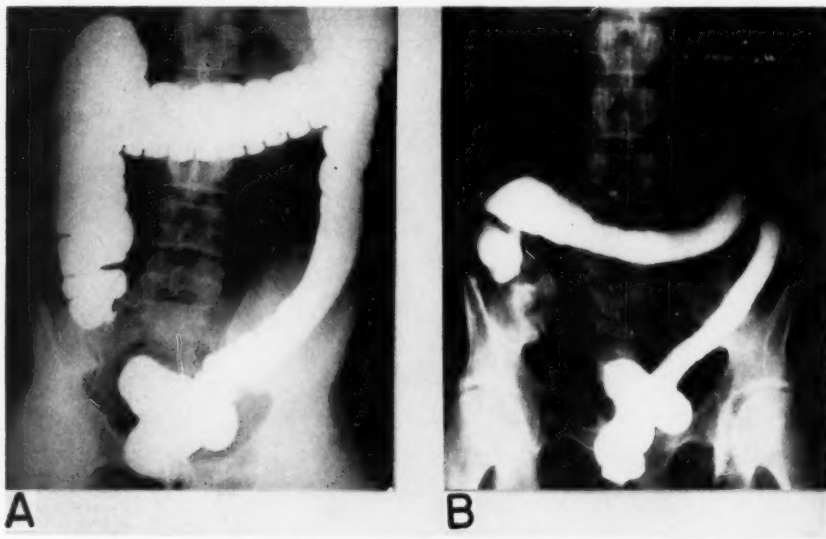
X-ray examinations of colon of patient with intractable ulcerative colitis showing progressive involvement of colon. Even though colon at present appears even more markedly involved patient is able to carry on a vigorous medical practice.
